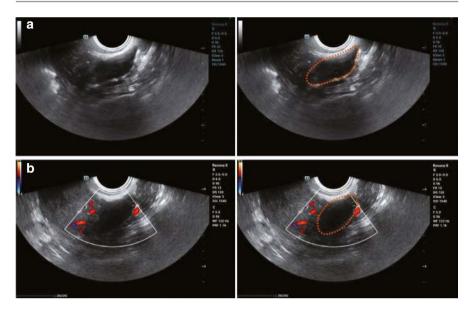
(a) The ovary is completely occupied by a mass, which appears as a solid lesion in the adnexal region, with well-defined borders, regular morphology, internal hypoechoicity, and posterior echo attenuation. The tumor is circled in orange. (b) Color Doppler ultrasound shows no blood flow within the mass (pathological testing confirmed the diagnosis as a fibroma). The tumor is circled in orange
